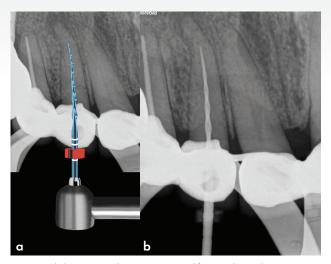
(a) Reciproc Blue R25 was used for initial canal preparation; (b) Periapical radiograph confirming the progress of the Reciproc Blue R25 instrument
